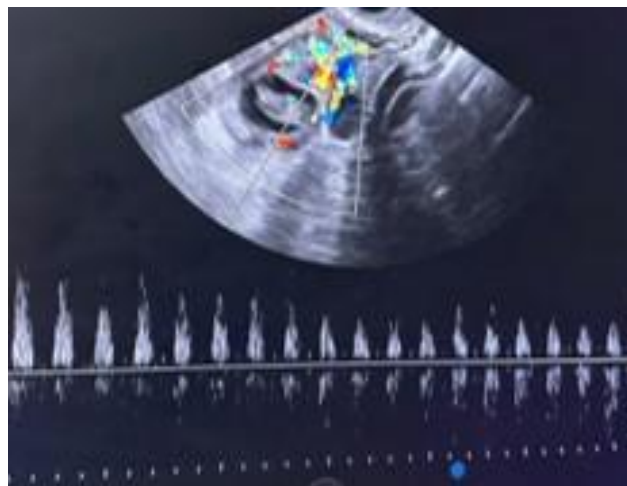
Transvaginal ultrasonographic image showing a left adnexal mass containing a live fetus with good cardiac activity.
